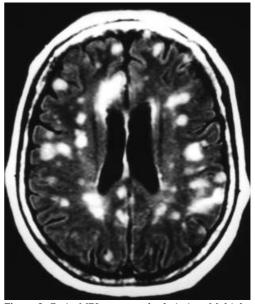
Brain MRI on second admission. Multiple, nodular metastasis to the cerebrum were observed.
